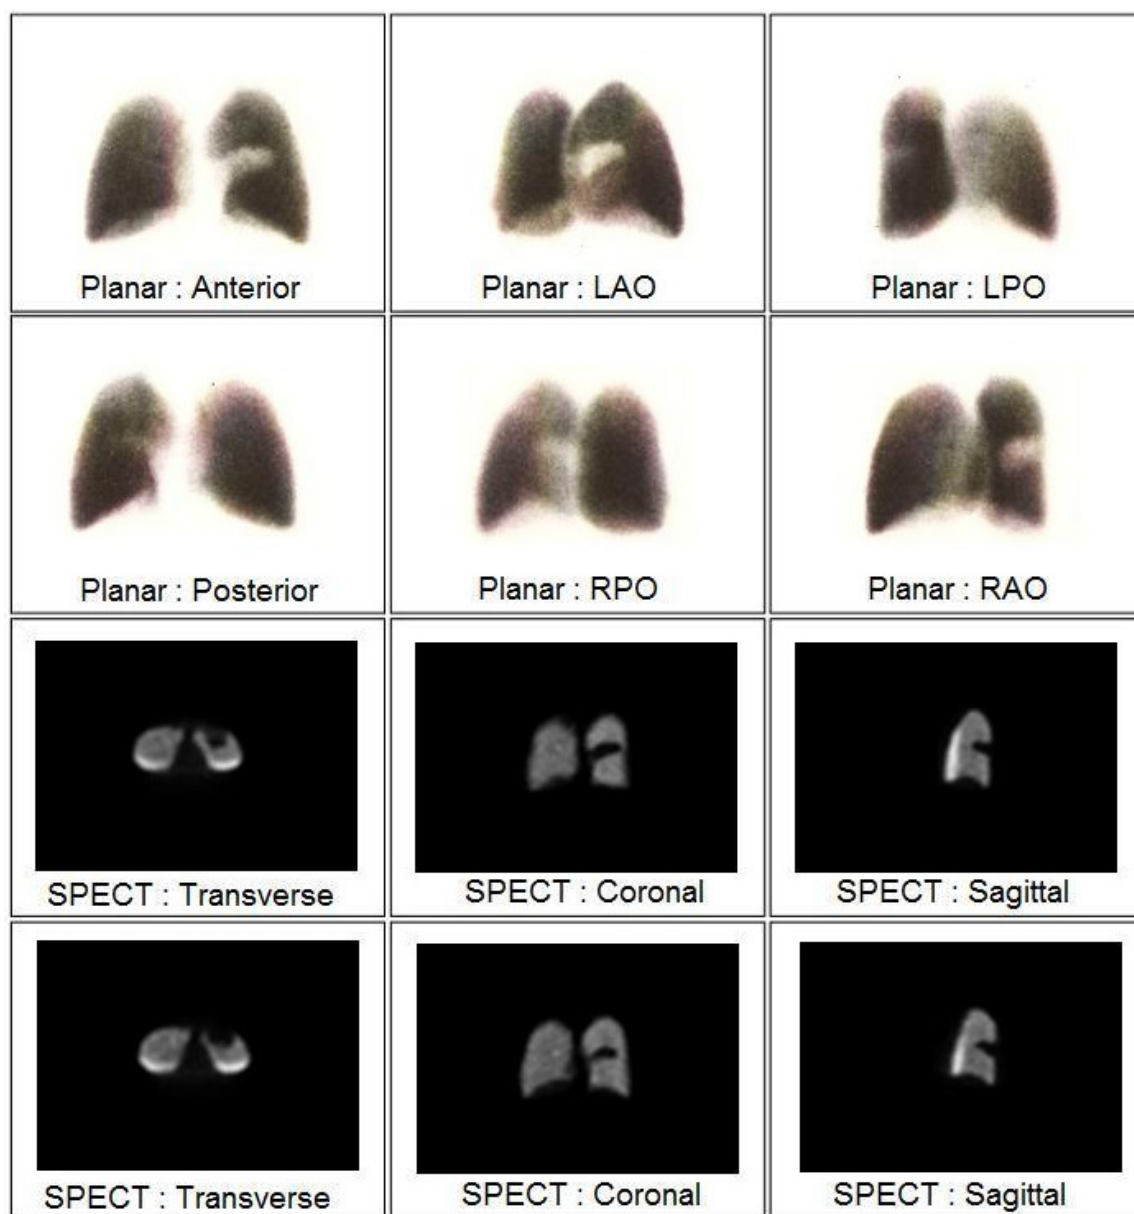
Planar and SPECT images of a perfusion defect within the lingular superior segment of the left upper lobe.
